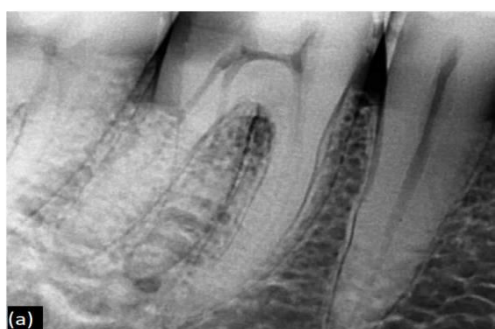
(a) Pre-operative radiograph of 46
